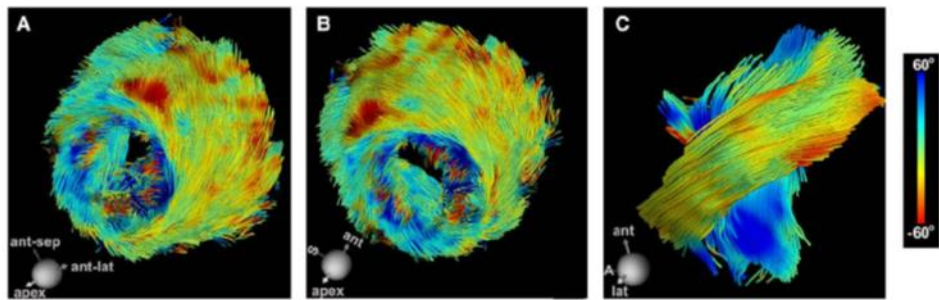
In vivo* diffusion tensor magnetic resonance imaging tractography of the left ventricle in a normal human volunteer.
